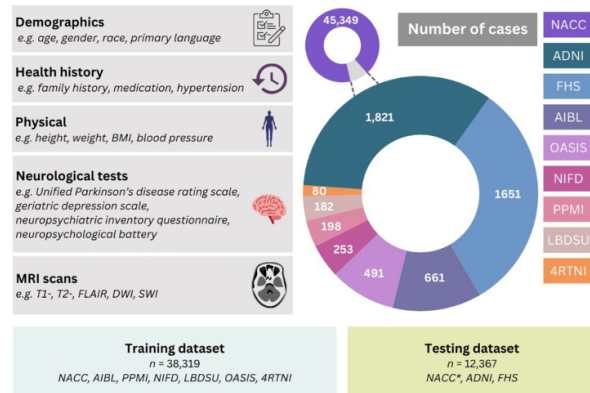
Our model for differential dementia diagnosis was developed using diverse data modalities, including individual-level demographics, health history, neurological testing, physical/neurological exams, and multi-sequence MRI scans. These data sources were aggregated from nine independent cohorts: the National Alzheimer's Coordinating Center (NACC), Alzheimer's Disease Neuroimaging Initiative (ADNI) dataset, the frontotemporal lobar degeneration neuroimaging initiative (NIFD), the Parkinson's Progression Marker Initiative (PPMI), the Australian Imaging, Biomarker and Lifestyle Flagship Study of Ageing (AIBL), the Open Access Series of Imaging Studies, the 4 Repeat Tauopathy Neuroimaging Initiative (4RTNI), and the Lewy Body Dementia Center for Excellence at Stanford University (LBDSU), and the Framingham Heart Study (FHS).
